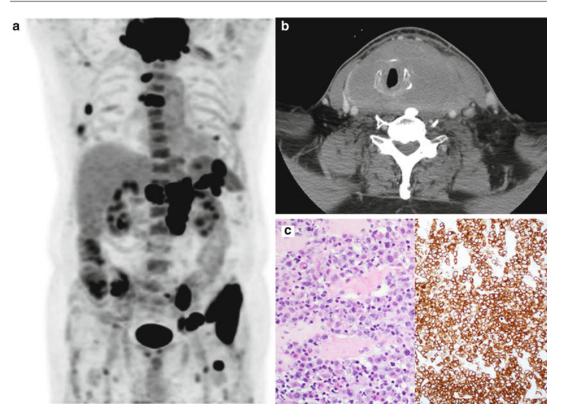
A newly diagnosed patient with thyroid lymphoma. (a) PET scan demonstrating enlarged thyroid with intense hypermetabolism with similarly avid lesions in the cervical, thoracic, retroperitoneal and pelvic lymph nodes. Additional lesions can be seen in the spleen, adrenal, and bone marrow. (b) CT scan of the neck demonstrating homogenous enlargement of the thyroid gland. (c) *Left*
